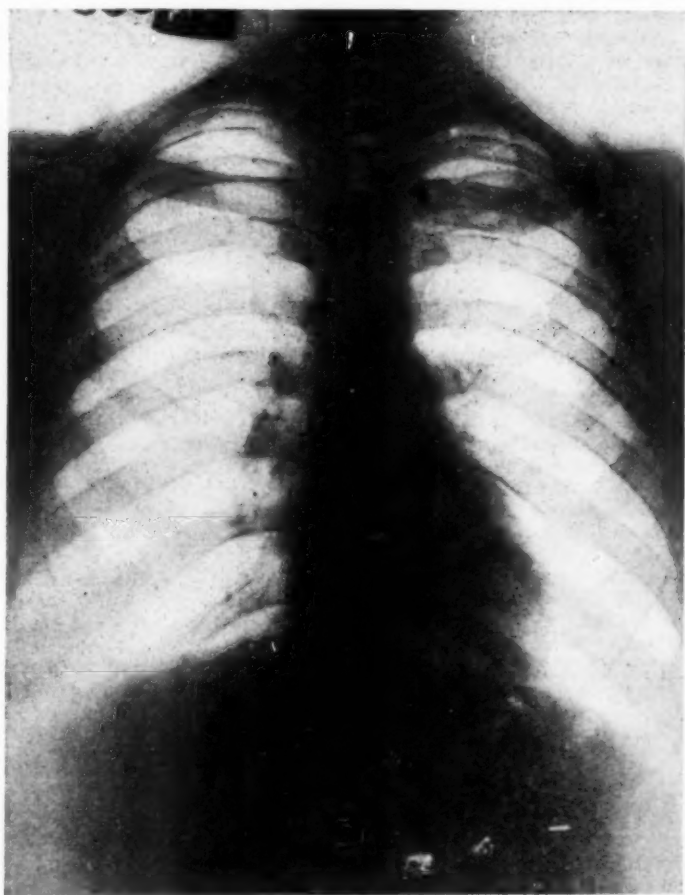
Roentgenogram, posterior-anterior view: A metallic fragment is seen at the border between right and left ventricle below the level of the aortic valve.
